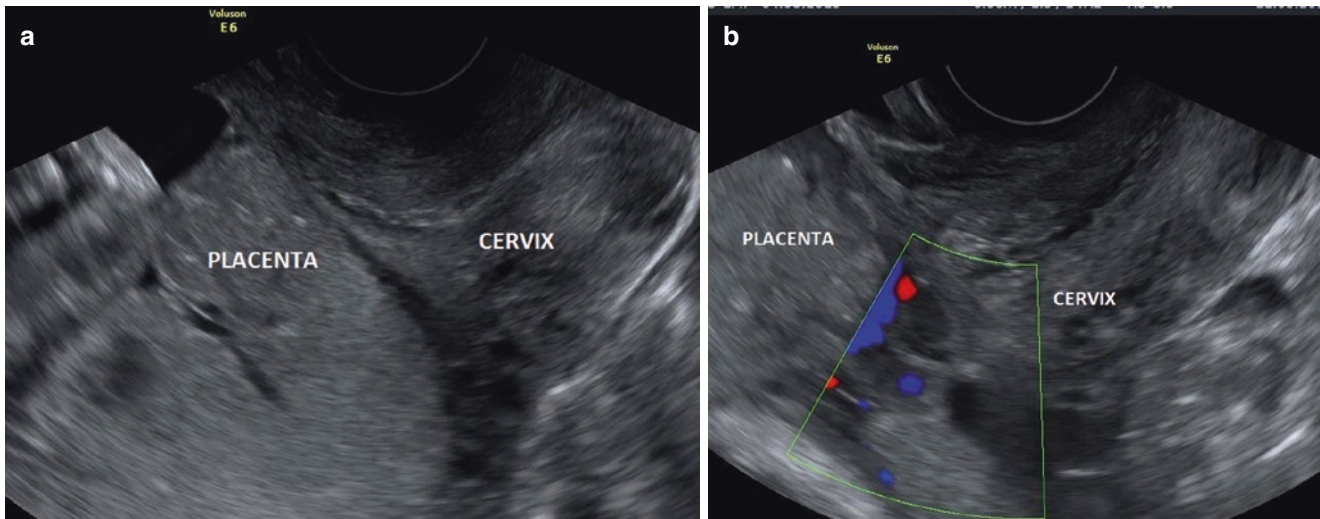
Transvaginal sonogram of total placenta previa (a) and marginal placenta previa (b)
